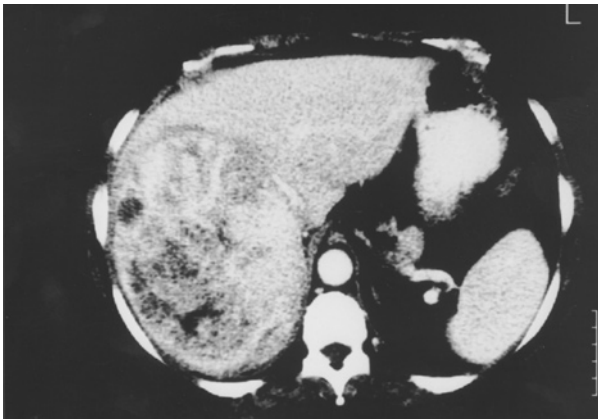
Computed tomographic image of a hepatic tumour with intralesional haemorrhage and necrosis. Typical features of a hepatocellular adenoma. This tumour was resected because of its large diameter.
